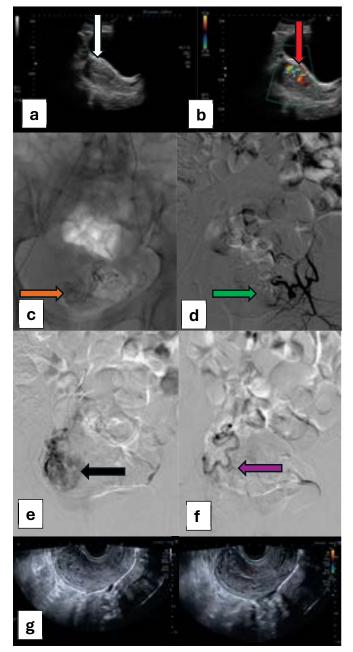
a) On transabdominal grey scale ultrasound, anterior wall of uterus appeared non-homogeneous with a few tiny cystic spaces (White arrow). b) These cystic spaces showed significant vascularity of mosaic pattern on colour doppler (Red arrow). c) Left uterine artery pre-embolization angiogram run shows abnormal bunch of vessels (Orange arrow). d) Left uterine artery post embolization run shows resolution of abnormal vascularity (Green arrow). e & f) Right pre and post-embolization runs show the high flow vascular malformation predominantly supplied by the right uterine artery (Black arrow) which was embolized by PVA particles (Purple arrow). g) Follow up ultrasound 2 years after the initial ultrasound shows no residual abnormal vascularity.
